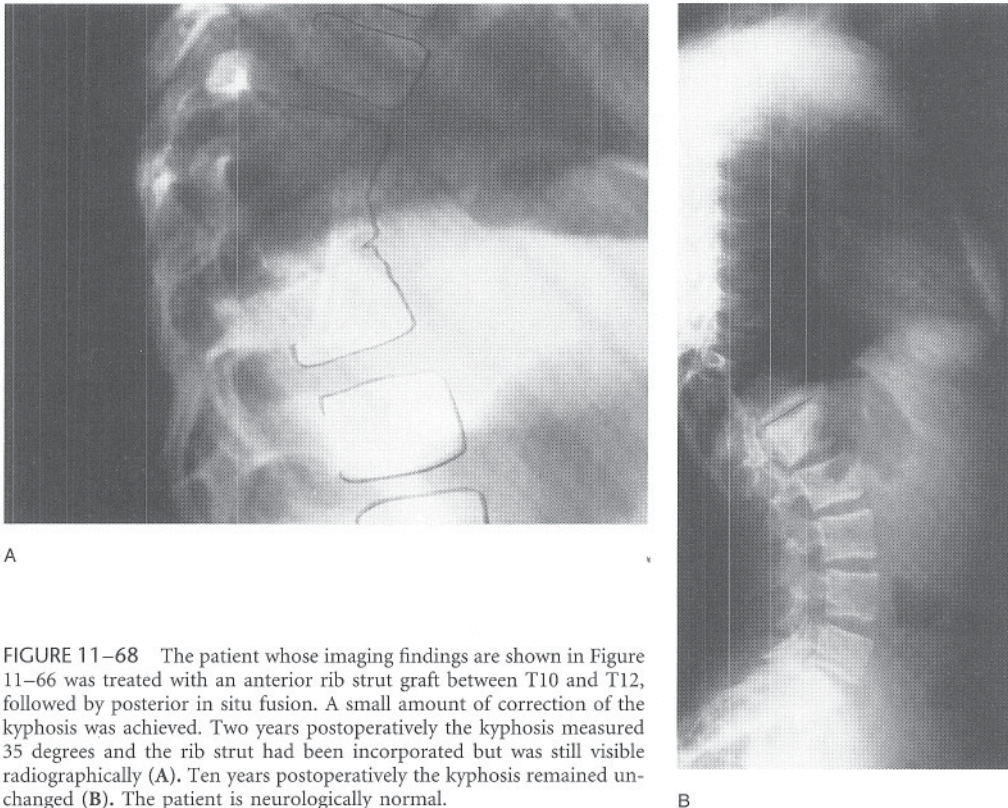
The patient whose imaging findings are shown in Figure 11–66 was treated with an anterior rib strut graft between T10 and T12, followed by posterior in situ fusion. A small amount of correction of the kyphosis was achieved. Two years postoperatively the kyphosis measured 35 degrees and the rib strut had been incorporated but was still visible radiographically (A). Ten years postoperatively the kyphosis remained unchanged (B). The patient is neurologically normal.
